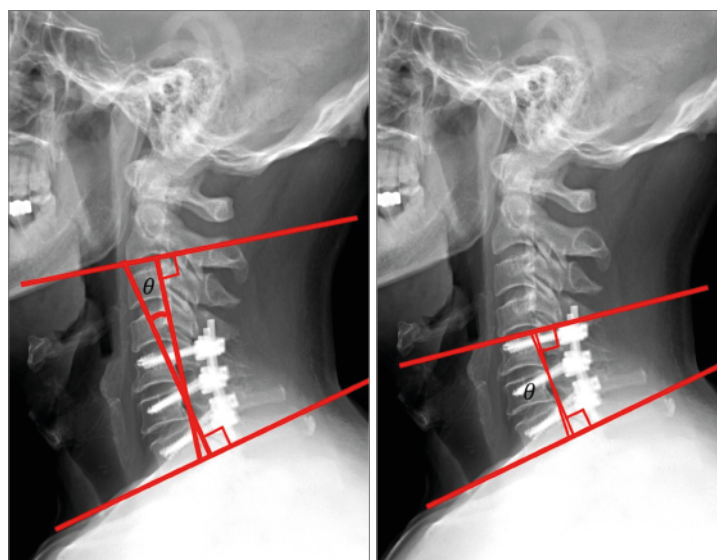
A lateral cervical X-ray image in the neutral position showing the Cobb's angle measurement between the lower borders of the C2 and C7 bodies.
